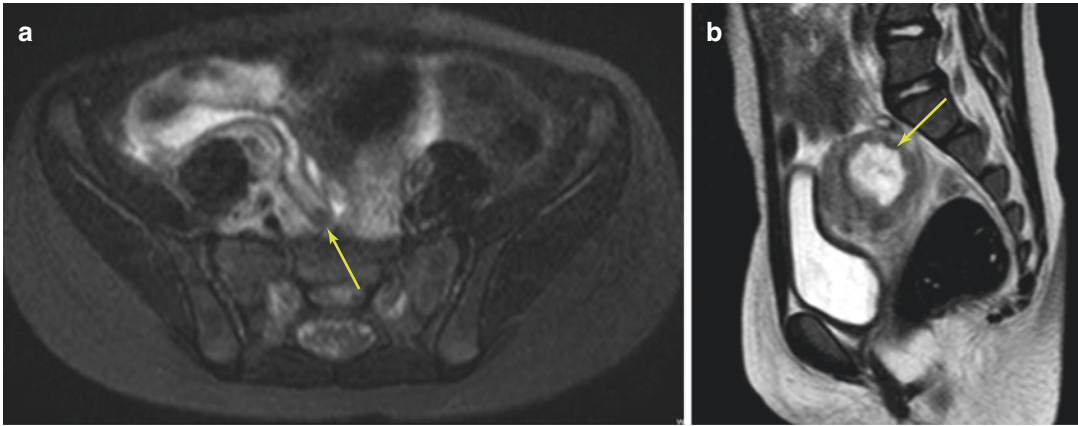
Perforated appendix in a 5-year-old girl: MR imaging T2-weighted sequences. (a) Deep perforated appendicitis (yellow arrow). (b) Associated pelvic abscess (yellow arrow)
